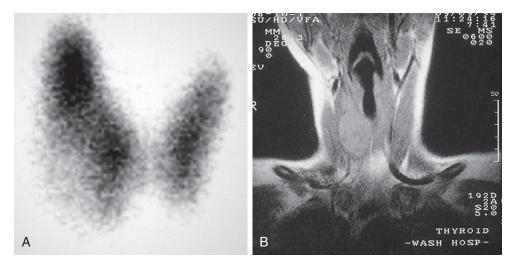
Nonfunctioning or "cold" thyroid nodule visualized by thyroid scan (A) and magnetic resonance imaging (MRI) (B) at surgery was found to be a benign follicular adenoma.
